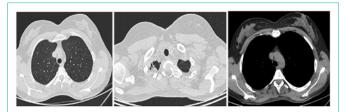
CT exam shows lobular ground glass opacities, especially localized in both upper lobes; fibrotic stripes and bands at both lung apex and lung bases. A tiny thymic gland is seen in anterior mediastinum.
